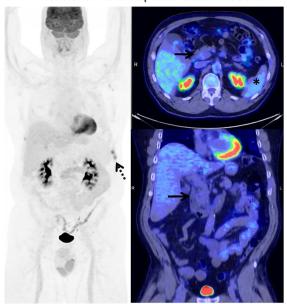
Follow-up ¹⁸F-FDG PET/CT images performed 8 months after initiation of gluten-free diet and chemotherapy/Immunetherapy for lung cancer show complete resolution of FDG uptake in duodenum (black arrows), spleen (asterisk) and bone marrow. Both spleen and bone marrow now show physiologic FDG uptake similar to/less than liver. There is also metabolic response in primary lung cancer. New FDG uptake was demonstrated in anterior lower left-sided rib fractures (dotted black arrows)
